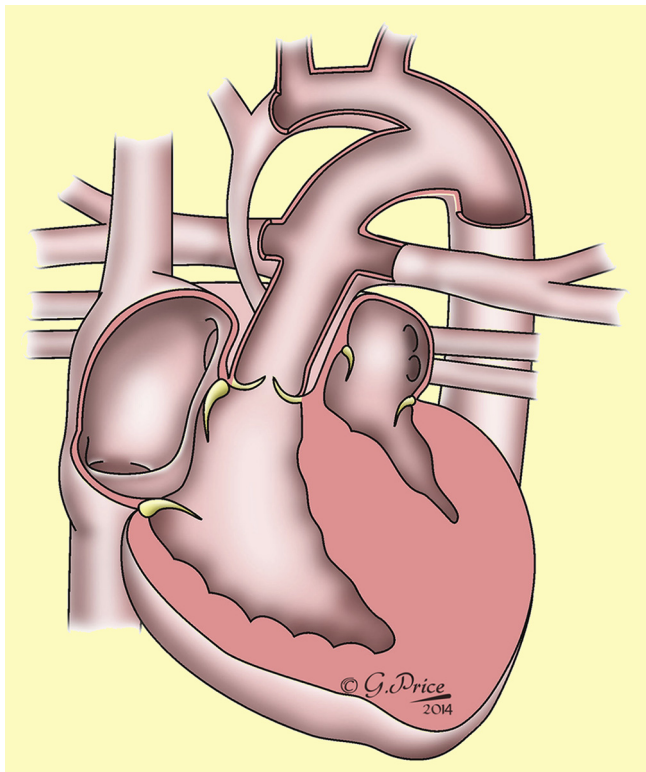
Hypoplastic left heart. The left-sided heart structures are hypoplastic and the arterial duct is maintained patent to sustain life in the immediate postnatal period. Four chamber transthoracic echocardiography view of hypoplastic left heart syndrome. (see video clip).
